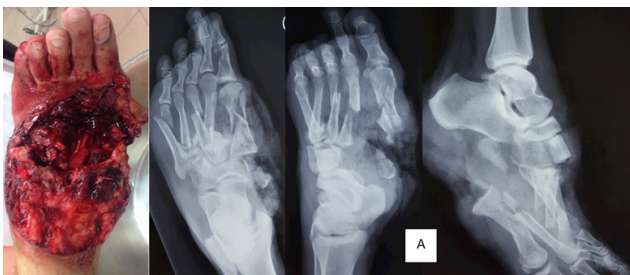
Figure A shows the initial appearance of the left foot post-trauma with the associated plain radiographs in antero-posterior, oblique and lateral views respectively (from left to right).
